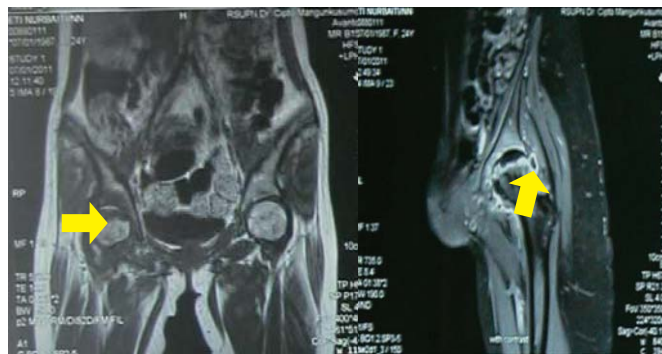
Patient's MRI showed collapse of the right femoral head (yellow arrow)
